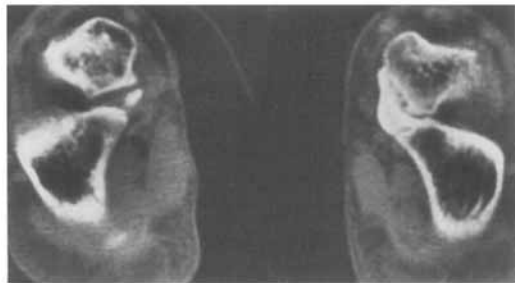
Case 10, aged 13 years. Negative contrast (air) CT talocalcaneonavicular arthrogram in right middle facet nonossified coalition—air (arrowheads) has failed to enter the narrow and ill-defined middle facet joint space.
